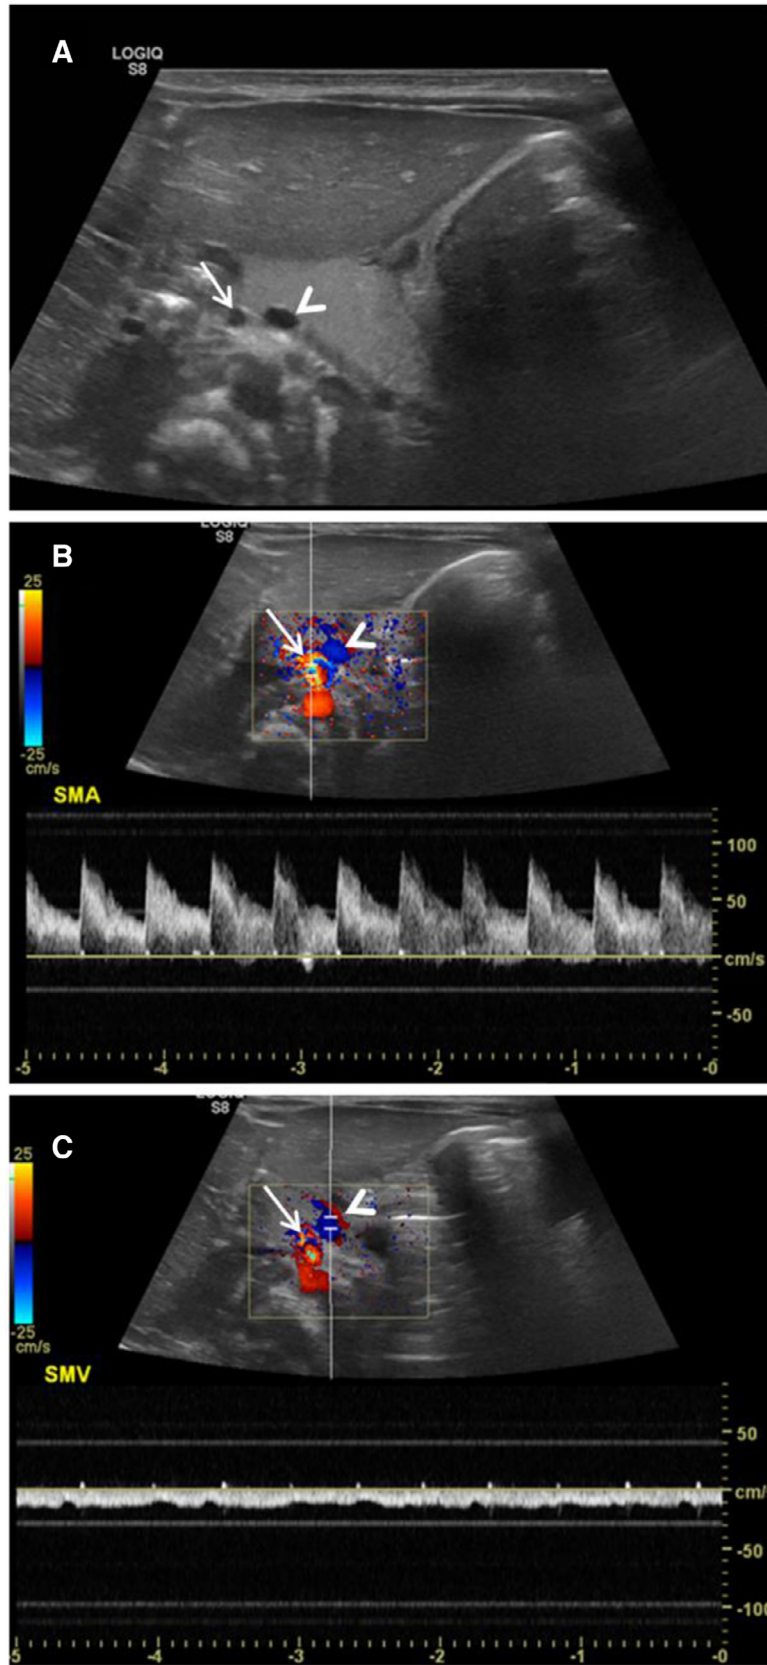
Abdominal ultrasound demonstrating the reversed relationship of the SMA (arrow) and SMV (arrowhead). The SMA typically sits on the left side of the SMV. (A) SMA and SMV identified. (B) Color Doppler and spectral waveforms of the vessel on the anatomic right demonstrate arterial flow, representing the SMA. (C) Venous waveforms are identified on the anatomic left, representing the SMV.
